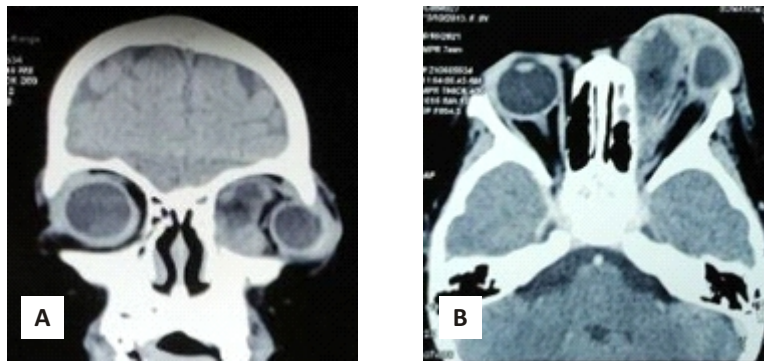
CT scan of the paranasal sinuses A. Coronal section B. Axial section
